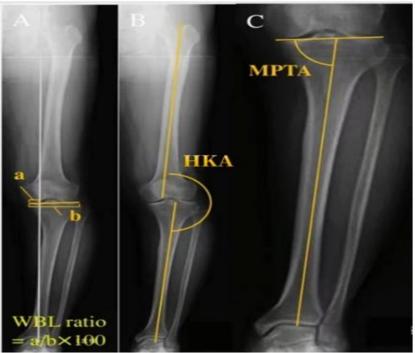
The radiographic measurements taken from an anteroposterior long-standing view of the lower extremity. (A) The weightbearing line (WBL) ratio was defined as the ratio between the distance from the medial tibial edge to the tibial insertion of WBL (a) and the tibial width (b). The weight-loading line was measured from the medial side, with the medial tibial edge at 0% and the lateral tibial edge at 100%. (B) The hip-knee-an kle (HKA) was the lateral angle formed between the anatomic
